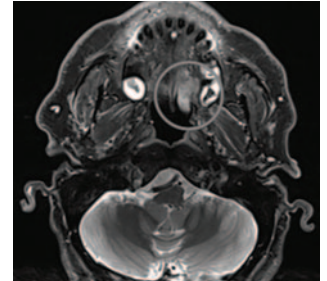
Case 2: Magnetic resonance imaging of the neck with contrast demonstrated the known lesion at the posterior hard palate.
